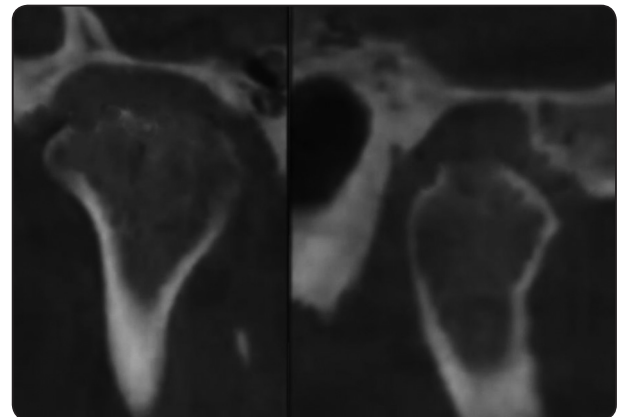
CT scan showing no evidence of new bone formation after 4 months postoperatively.
